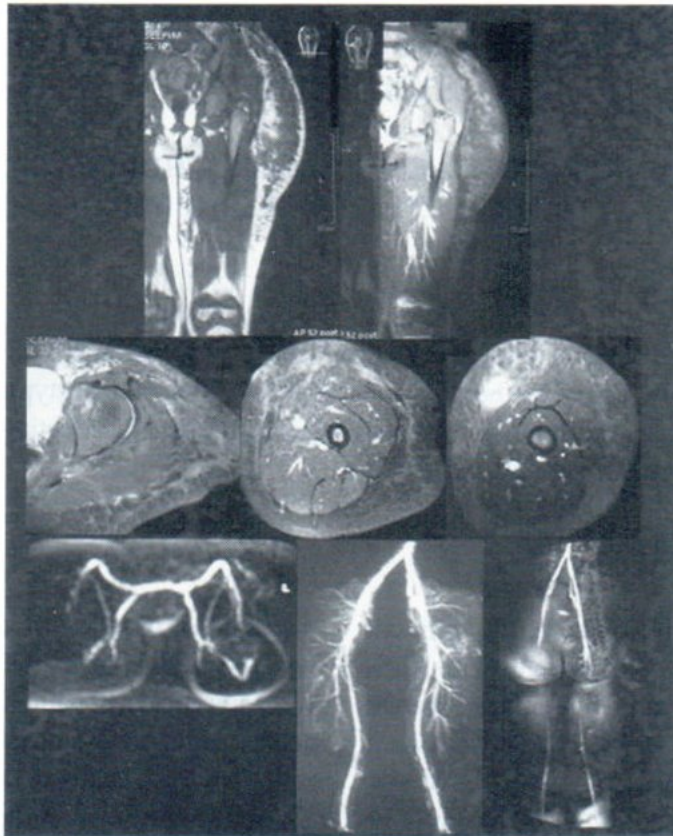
A 3-year-old female patient presented with progressive enlargement of Lt. thigh and erythematous macule since birth. MRI and MRA Lt. leg showed a soft tissue mass lesion from the level of iliac brim to the above knee region with serpentine flow void structures. Heterogenous soft tissue and vascular enhancement was noted on post Gadolinium injection study. Relative minimal larger of Lt. leg arteries were observed.
